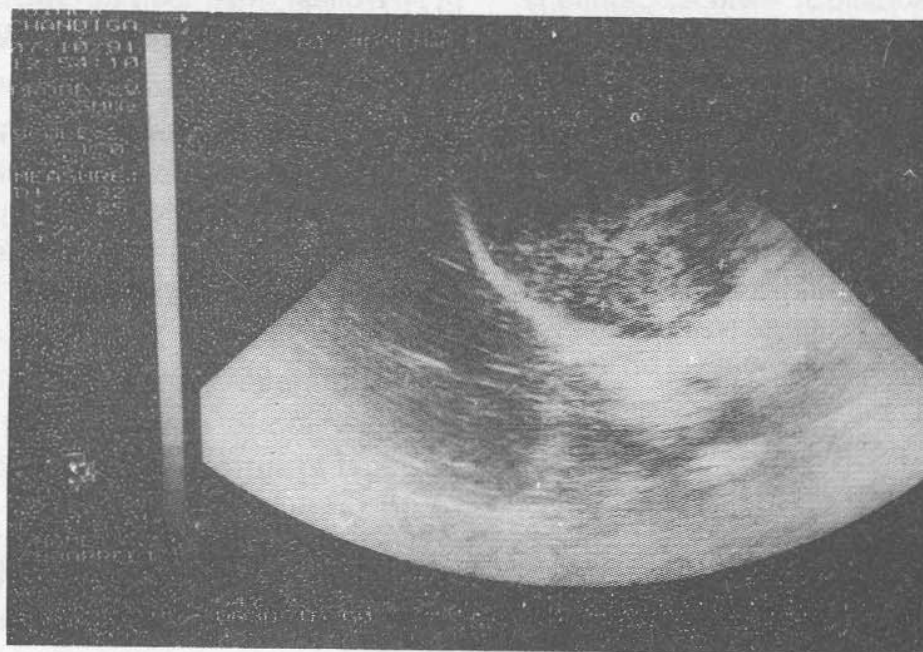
(a). Ultrasound and CT scan abdomen.
